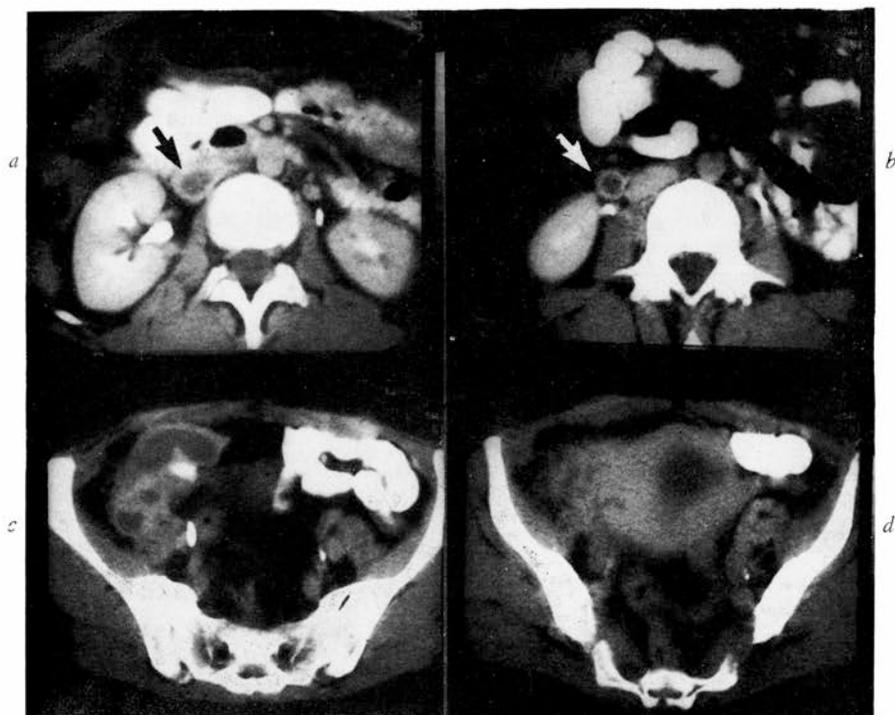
Case 4: Right puerperal ovarian vein thrombosis. CT scans at different levels of the pelvis: *a*) filling defect (arrow) in the inferior vena cava; *b*) filling defect (arrow) in dilated right ovarian vein; *c*) adnexal mass with low-density tubular structure within it; *d*) the adnexal mass seen to the right of a fluid filled uterus.
